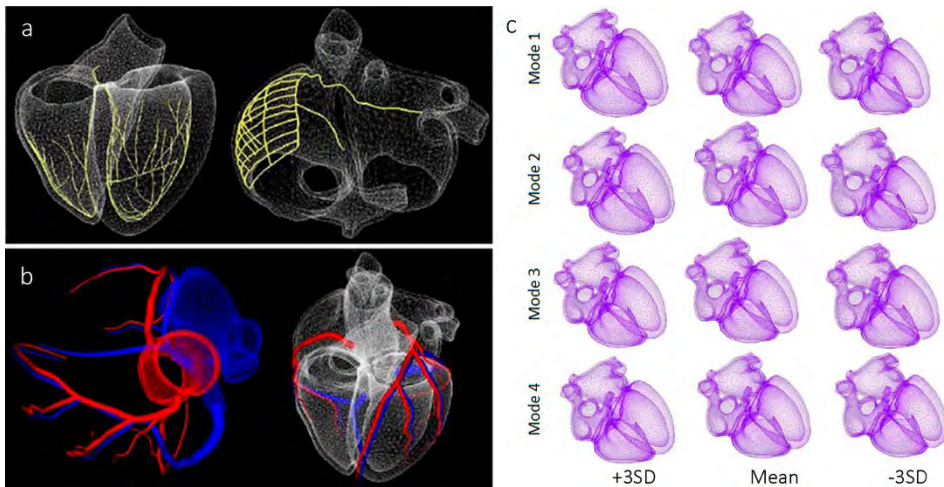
Whole-heart cardiac atlas constructed using MS-CT images from 100 human subjects. (a) Wireframe representation of the atlas showing the representation of the CCS included in the model at ventricular (*left*) and atrial level (*right*). (b) Wireframe representation showing the model of the main coronary vessels included in the cardiac atlas. (c) The four principal modes of variation of the whole-heart atlas. Adapted from (Ordas *et al.*, 2007)
